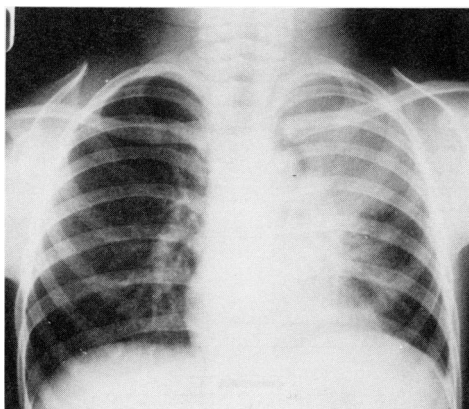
First chest X-ray film (Case 3).
